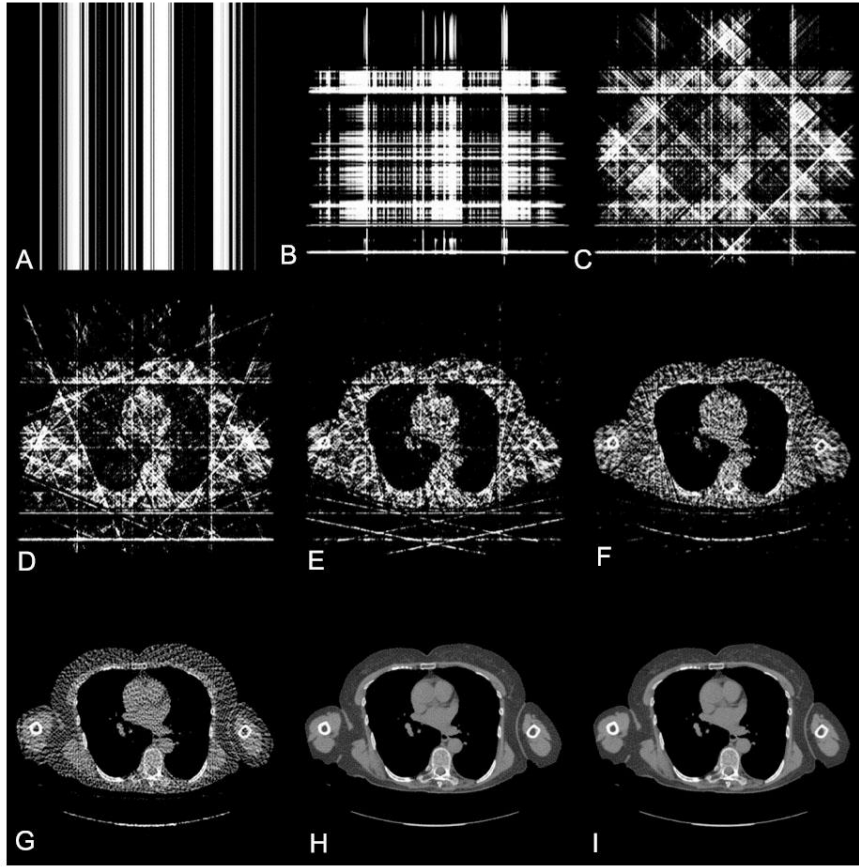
CT images reconstructed using filtered back projection. Number of acquired transmission profiles were A) 1, B) 2, C) 4, D) 8, E) 16, F) 32, G) 64, H) 256 and I) 1024. (Figure used with permission from Dance et al. 2014)
